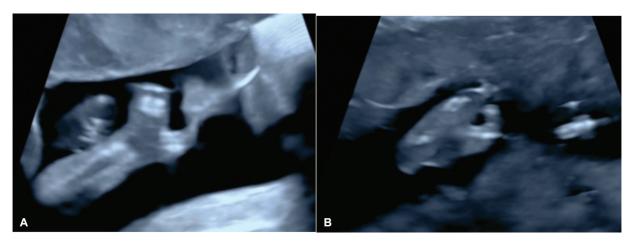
Four dimensional volume contrast imaging (4D VCI) skeletal mode ultrasound showing loss of central 2 digits and syndactyly of 4th and 5th digits in fetal hand with very short proximal phalanges in remaining digits (A) and cleft foot with syndactyly of 1st and 2nd toes along with absent proximal phalanges (B).
